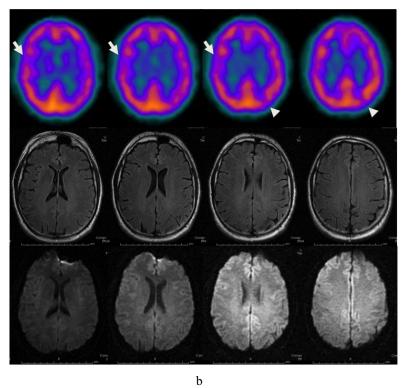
Comparison of brain SPECT and MRI findings in a 15 yo male at baseline and at follow-up. a: Baseline: minimal perfusion defect of right frontal cortex (arrows) and *left parieto-occipital border* (arrowheads) at SPECT. No focal alterations detected with MRI (FLAIR and DWI). b: Follow-up: disappearance of the previously observed perfusion defects and onset of a new minimal hypoperfused area on left fronto-parietal cortex (arrows). No focal alterations detected with MRI (FLAIR and DWI).
